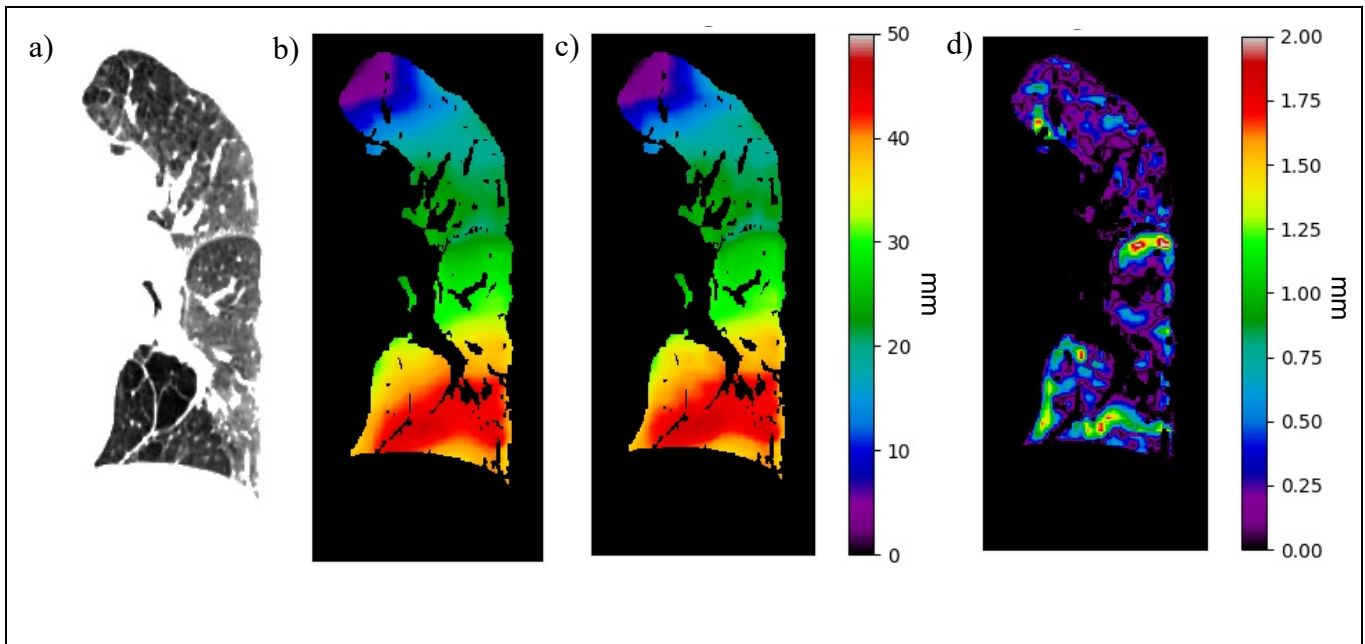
CT source image and displacement magnitude distributions for (a) registration and (b) model-generated outputs; (c) Difference map (in mm) in RV geometry
